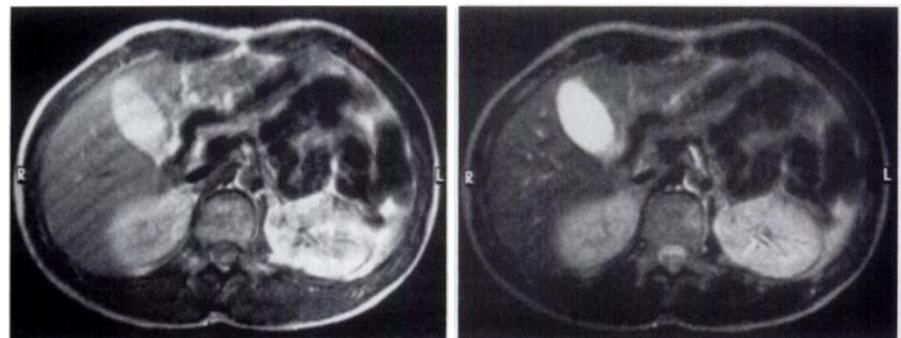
Transverse postcontrast intermediately weighted (a) (2,100/29, 0.5 T) and T2-weighted (b) (2,100/100, 0.5 T) images of a trial 1 patient with cancer of the testis with lung metastases. CT and US reveal possible metastasis in the hilum of the left kidney. The contrast material-filled intestines help rule out a metastasis in the region.
